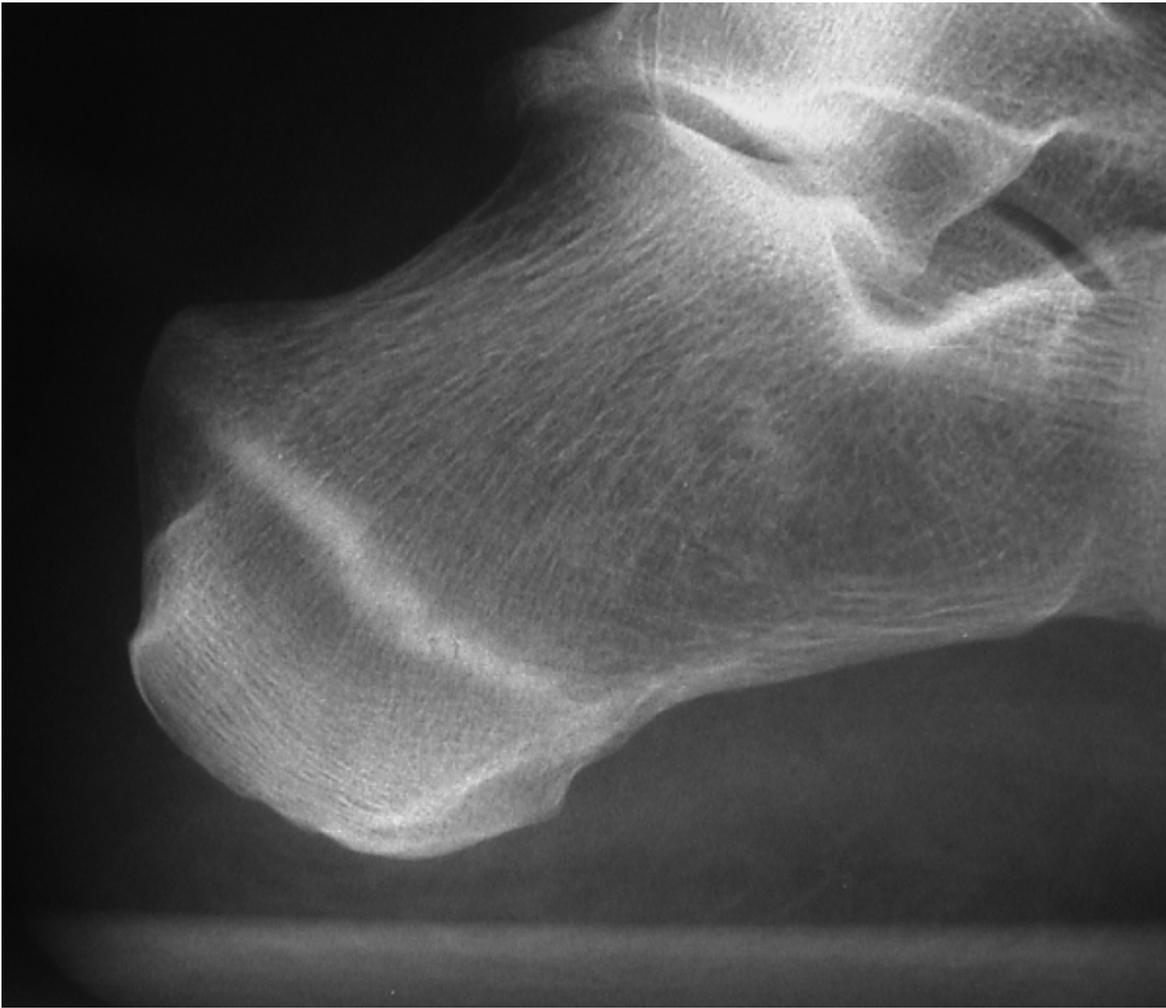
11 Persistent heel pain in this 29-year-old woman was initially attributed to plantar fasciitis at another institution, where her radiographs were negative. After an interval of 4 weeks, the stress fracture of the calcaneal tubercle became apparent. (Courtesy of James W. Brodsky, MD.)
